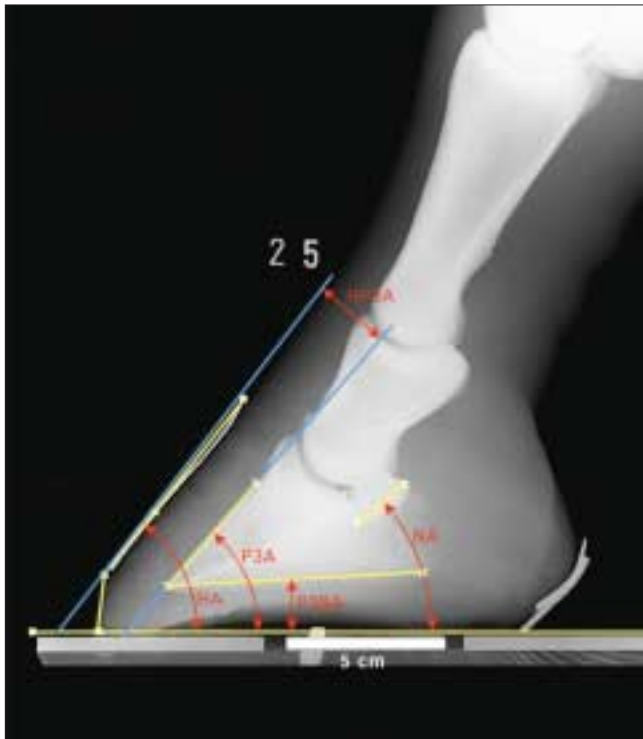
Angle measurements of the laterolateral radiograph. P3A: P3 angle, from the dorsal midline of P3 to the ground plane. NA: Navicular Angle, the angle between the axis of the navicular bone and the ground. HA: Hoof Angle, the angle between the dorsal hoof wall and the ground, as it would be read from a physical “hoof gauge.” HP3A: hoof-P3 angle, the angle of the lines formed by the dorsal hoof wall and the dorsal wall of P3. P3BA: P3 bottom angle, the angle formed between the bottom (palmar surface) of P3 and the ground.
